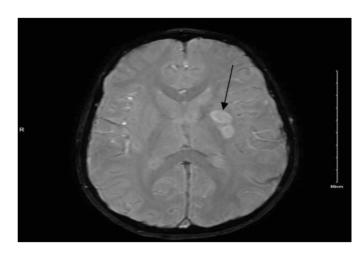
Brain MRI T2 Multiple left cerebral hemisphere lesions with abnormal signal intensity are noted in the left basal ganglia at putamen and caudate nucleus (black arrow).
